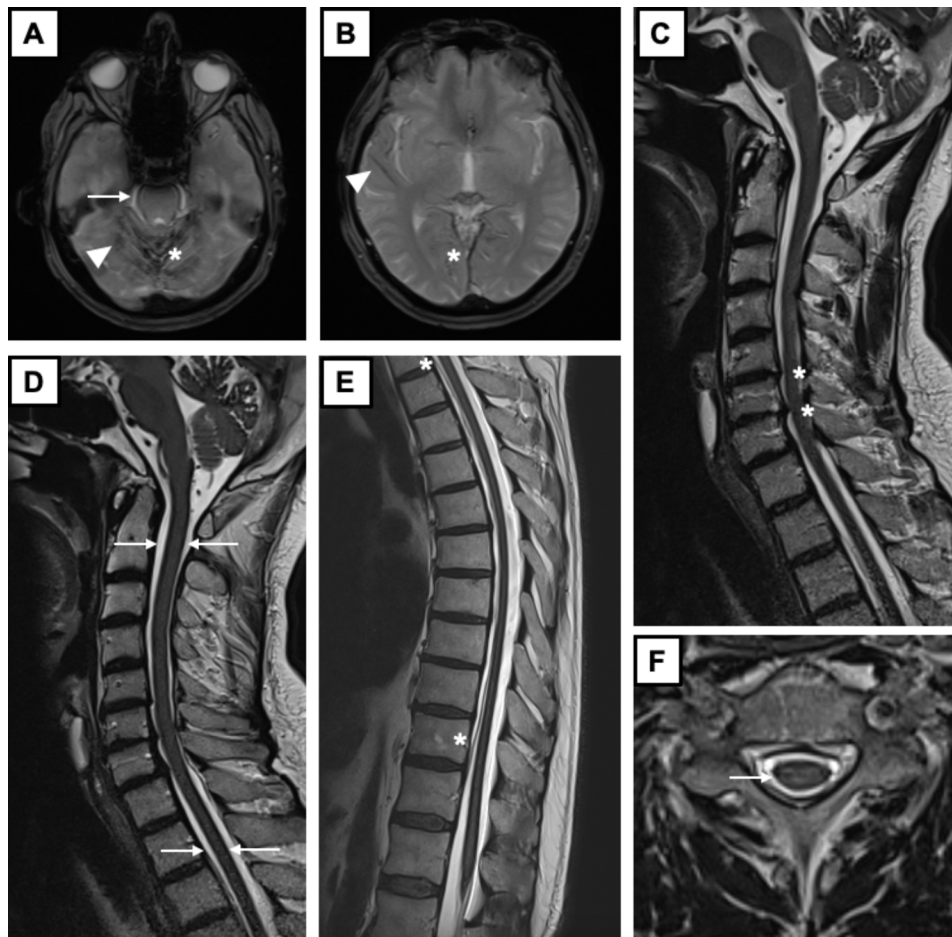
MRI images of July 2019. A: axial GRE image showing infratentorial hemosiderin deposition (pons (white arrow), cerebellar vermis (white asterisk), cortex of cerebellar hemispheres (white arrowhead)). B: axial GRE image showing supratentorial hemosiderin deposition (right temporal and insular cortex (white arrowhead), bilateral medial parieto-occipital cortex (white asterisk)). C: T2-TSE sagittal image of the cervical cord showing osteophytes and disc protrusions at C5-6-7 levels (white asterisks). D and E: T2-TSE sagittal images of the cervical and dorsal cord, respectively, showing hypointense rim of hemosiderin deposition along the entire length of the cord (white arrows) and a VLISFC extending from T2-T3 level to T11 level (white asterisks). F: axial T2-SPACE image at C6 level showing the hypointense rim of hemosiderin deposition on the cord surface (white arrow) but no signal alterations of the anterior horns. *GRE, gradient-recalled echo. MRI, magnetic resonance imaging. TSE, turbo spin echo. VLISFC, ventral longitudinal intraspinal fluid collection*
